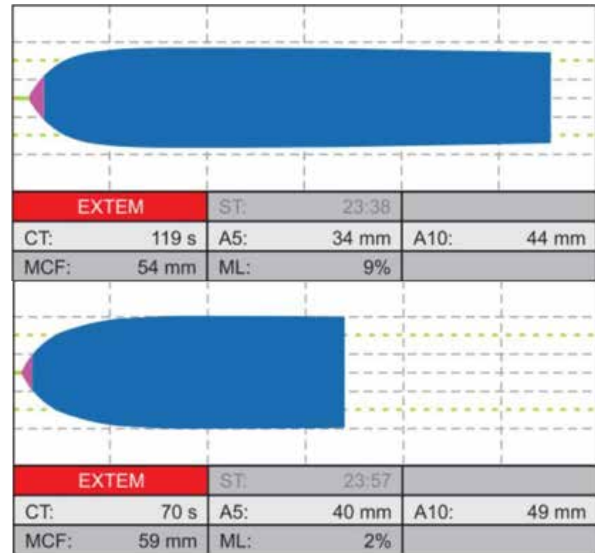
An example of an extended clotting time in the first EXTEM (CT 119secs) which was corrected to 70 secs post administration of four factor prothrombin complex concentration (Görlinger et al 2019). Reproduced with permission (CC BY 4.0).
